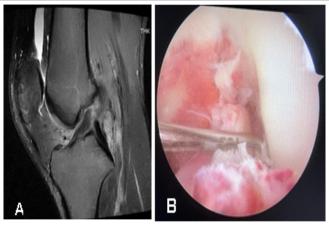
(a) Magnetic resonance imaging showing complete tear and (b) arthroscopy showing stable tear of lateral meniscus.
